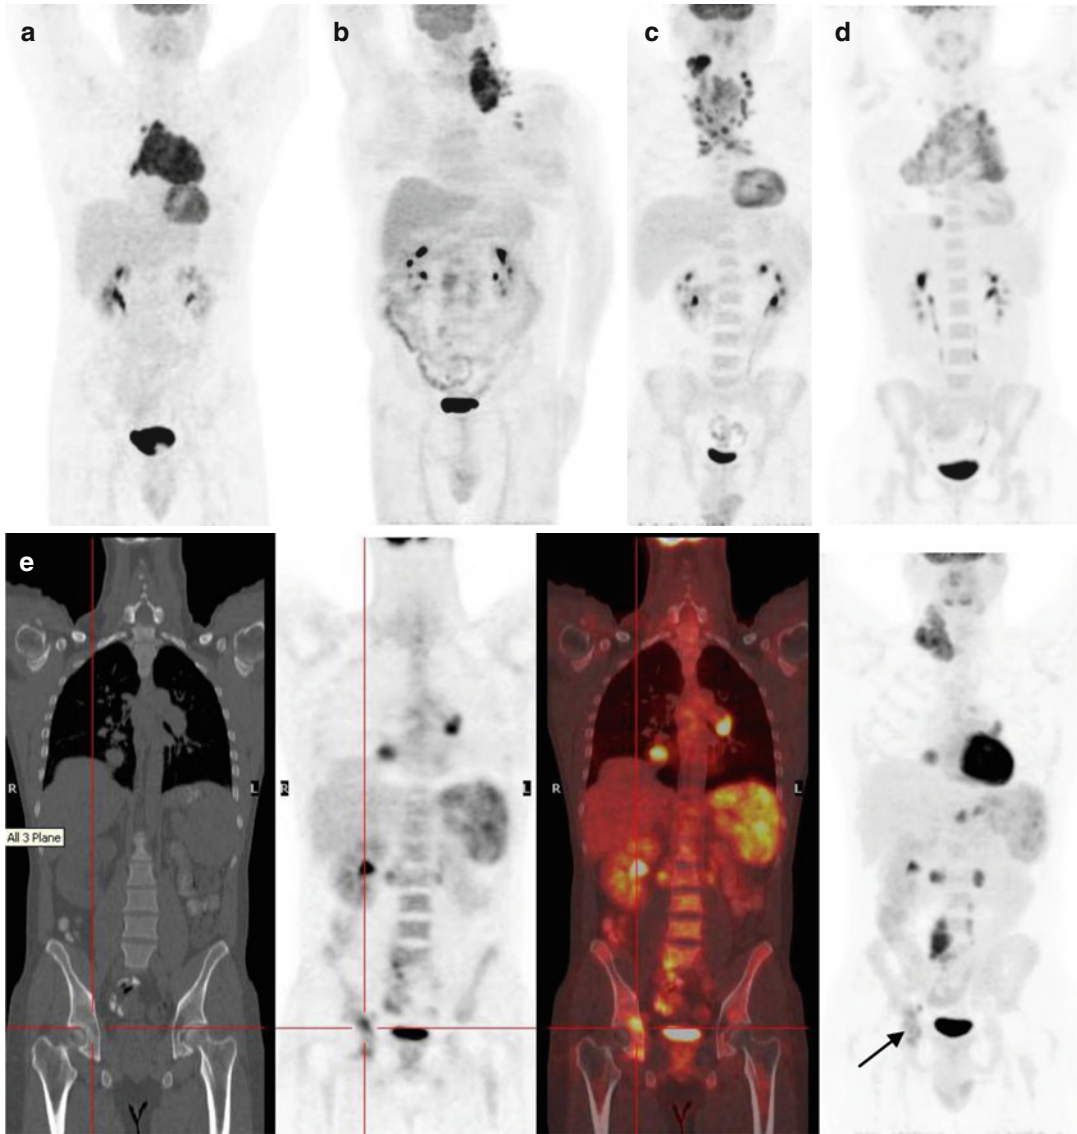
Patterns and grading of bone marrow 18-FDG uptake. (a) No increased bone marrow 18-FDG uptake in the bone marrow (score 1). (b) Diffusely increased bone marrow 18-FDG uptake but less than the uptake of the liver (score 2). (c) Diffusely increased bone marrow 18-FDG uptake equal to the uptake of the liver (score 2). (d) Diffusely increased bone marrow 18-FDG uptake exceeding the uptake of the liver (score 3). (e) Unifocal 18-FDG uptake (score 4) at the right iliac bone with no associated CT finding (From left to right: Coronal CT, PET and Fused images (red cross) and MIP PET image
